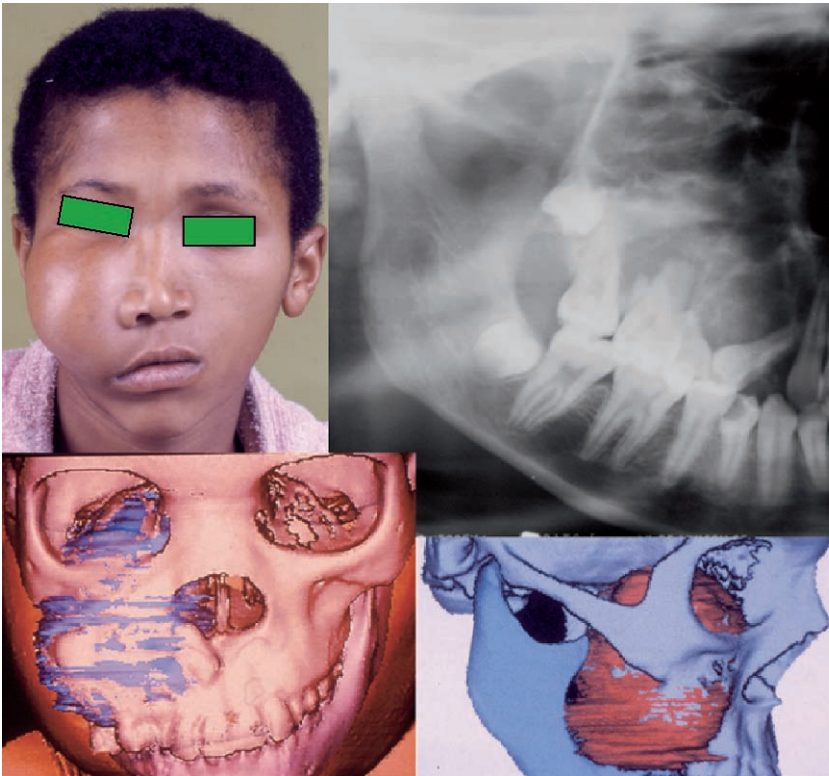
Cementifying-ossifying fibroma displacing and occupying the whole maxillary sinus space on the right side. *Lower images* represent reformatted computed tomography reconstruction of this benign neoplasm
